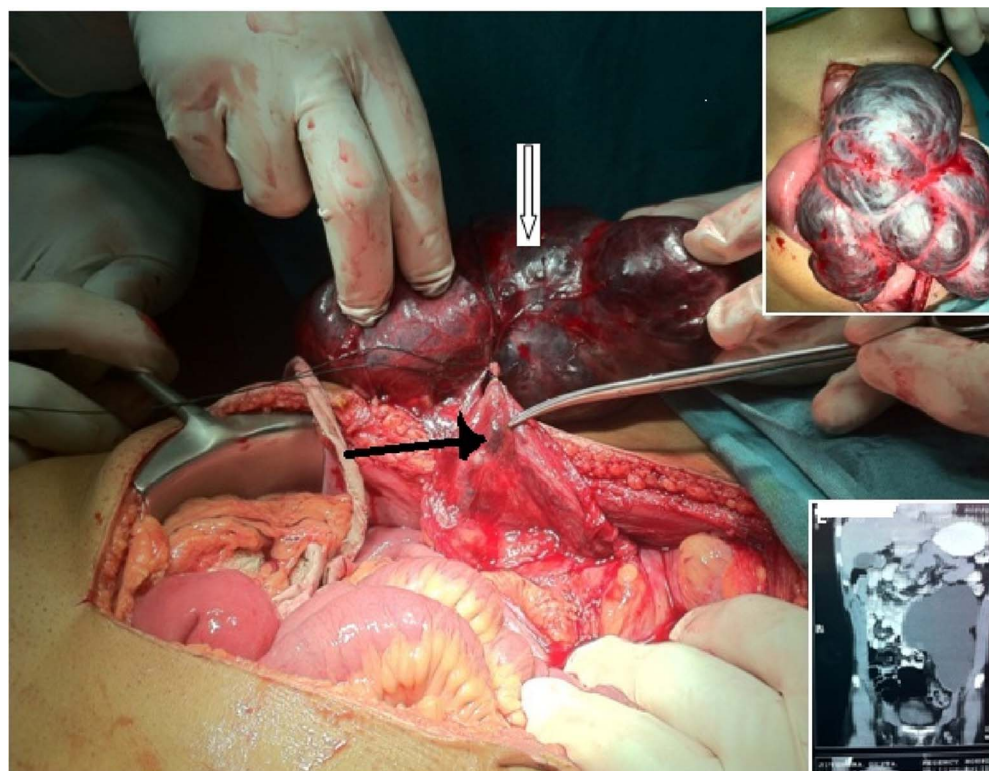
Abdominal varicocele: operative picture. Lower inset: CT scan of the abdomen showing a cystic mass. Upper inset: the vascular mass. Arrow: testicular vessels (L).
